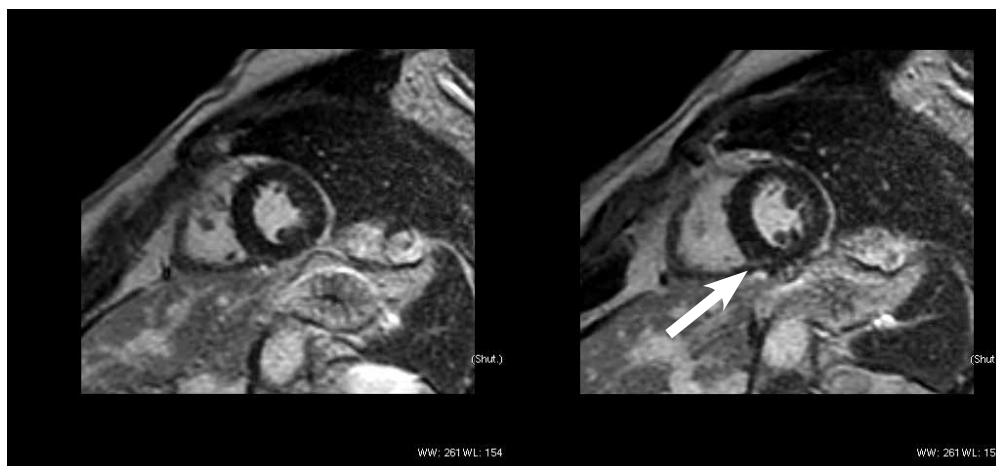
Baseline (left) and follow up (right) cardiac magnetic resonance imaging with gadolinium enhancement studies images, the latter showing the appearance of delayed gadolinium enhancement (white arrow).
